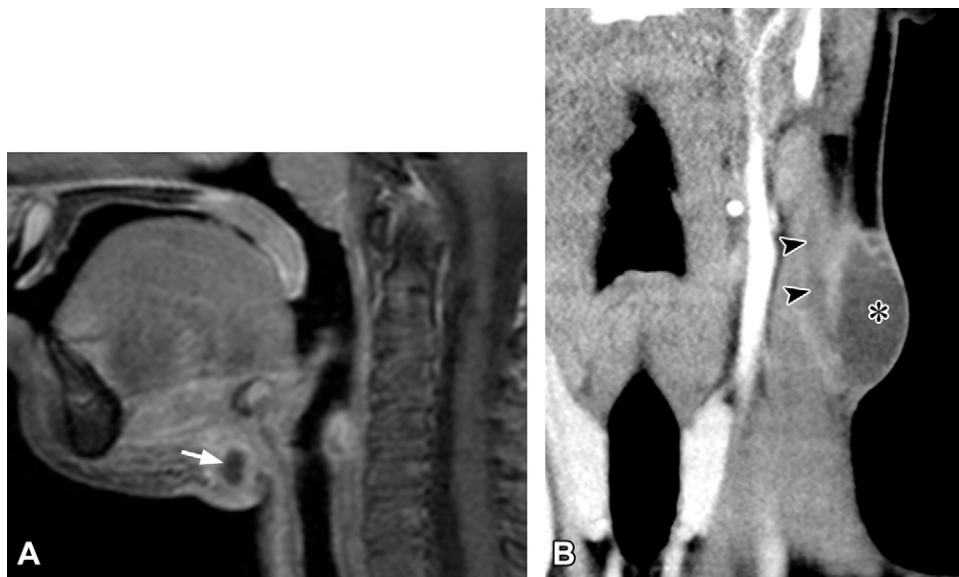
Infected congenital cysts in two pediatric patients. (A) Sagittal contrast-enhanced T1W FS MR image in a 6-year-old boy with neck swelling shows a peripherally enhancing thyroglossal duct cyst (arrow) anterior to the hyoid, with surrounding inflammatory change. (B) Coronal CECT image in a 16-year-old adolescent boy with recurrent neck swelling shows an infected second branchial cleft cyst (*) with an adjacent enhancing sinus tract (arrowheads).
